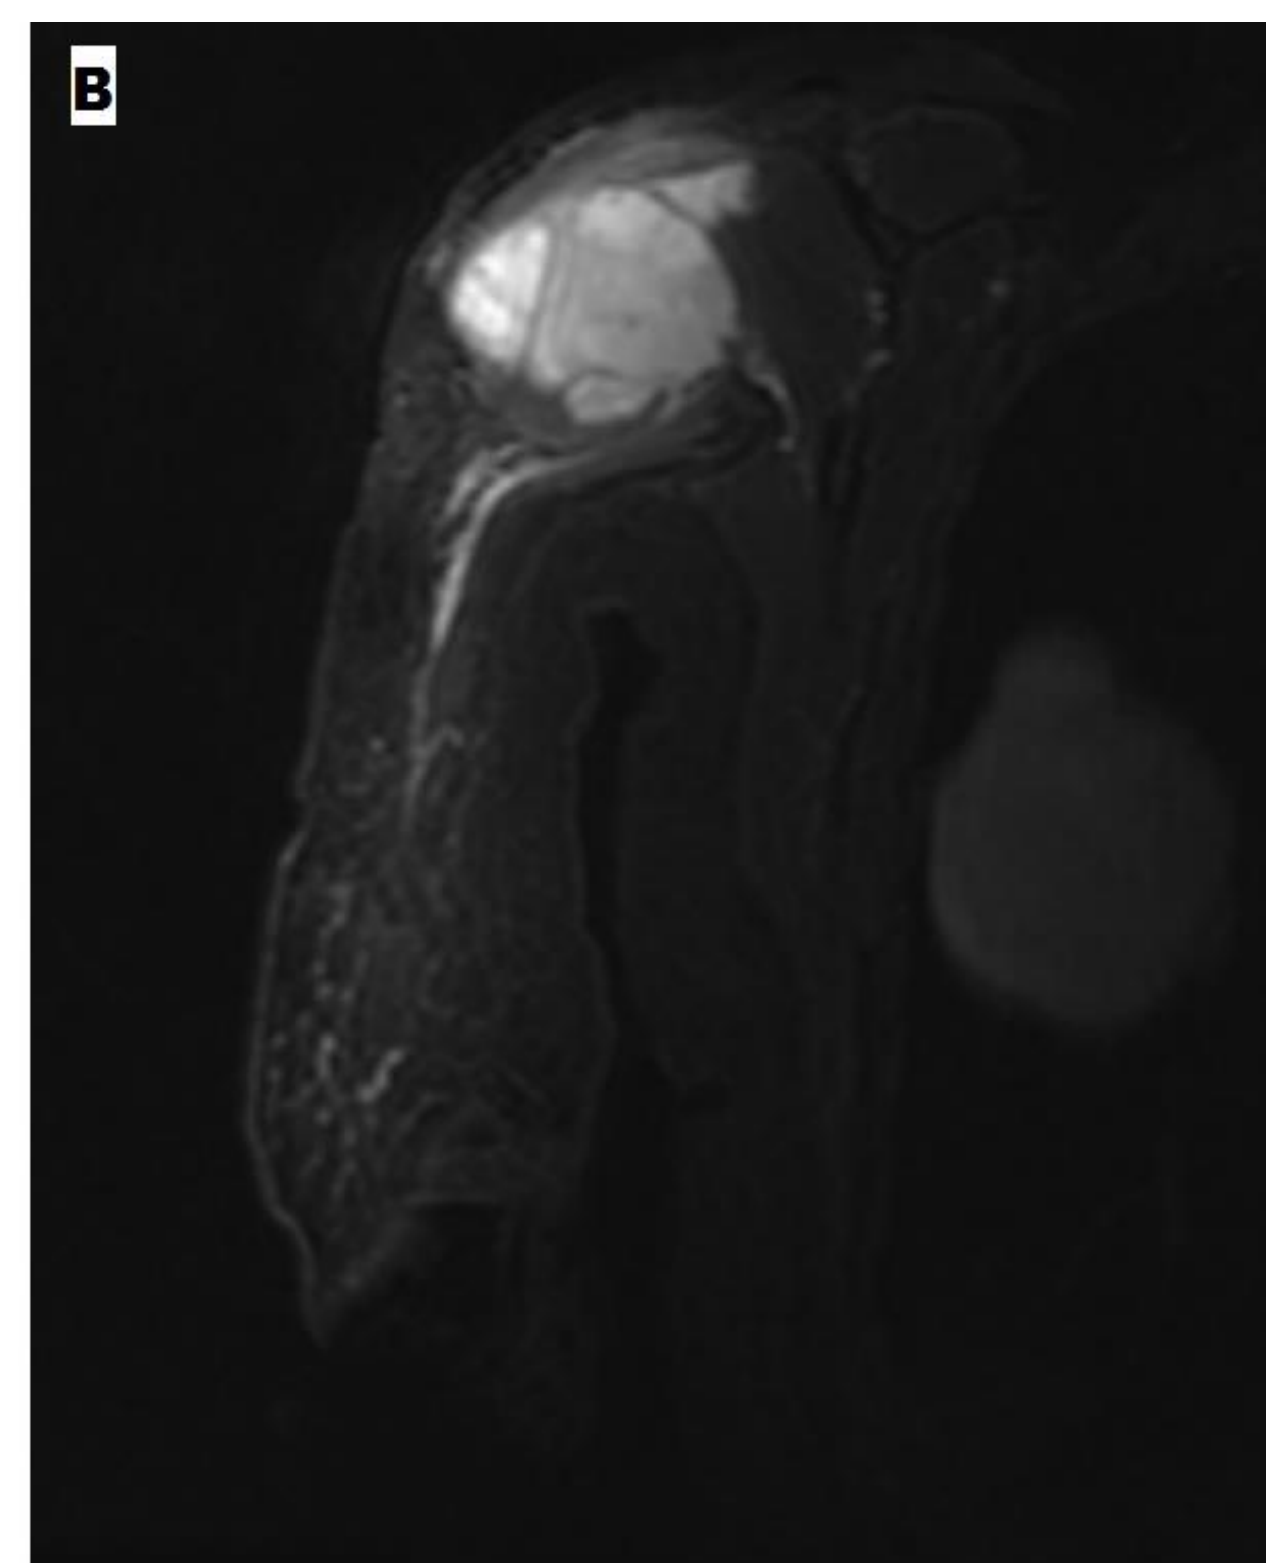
Magnetic resonance imaging of the right upper extremity showing heterogeneous soft tissue mass measuring 6.8 x 7.5 x 7.6cm.
